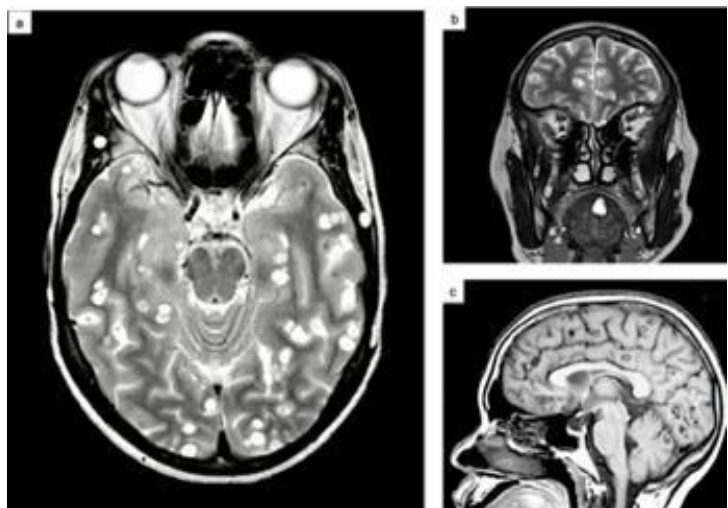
a) Brain Magnetic Resonance Imaging (MRI) transverse view demonstrated diffuse cystic lesions with thin, enhancing walls with central hyperintense foci in the cerebrum, cerebellum, lateral ventricles, and craniofacial and neck soft tissues, consistent with disseminated cysticercosis with vesicular stage neurocysticercosis with a racemose neurocysticercosis component. b) Brain MRI coronal view demonstrated diffuse cystic lesions with central hyperintense foci in the craniofacial and neck soft tissues. c) Brain MRI sagittal view demonstrated features of disseminated cysticercosis with vesicular stage neurocysticercosis with racemose neurocysticercosis component.
